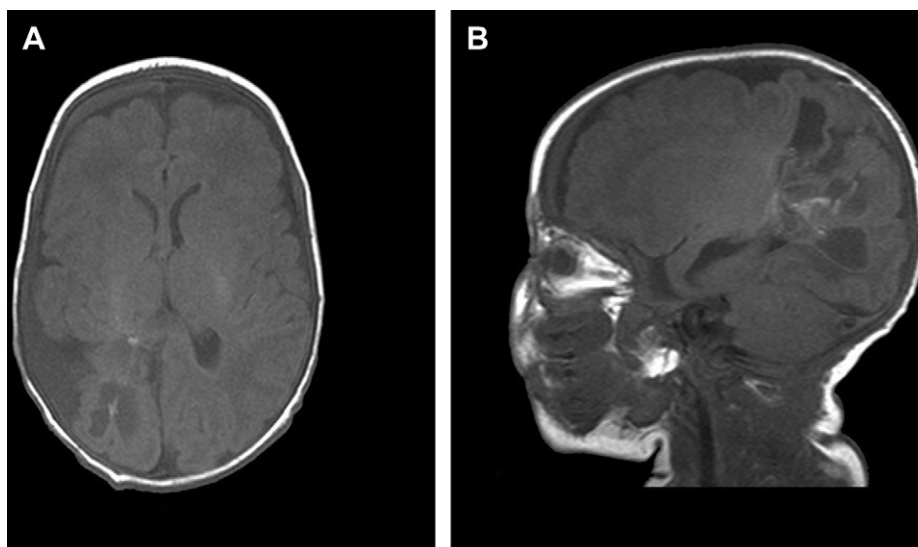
Postoperative magnetic resonance imaging of the brain showing (A) right-sided cortical thinning and atrophy with temporo-parietal gliosis and (B) *ex vacuo* dilatation of the temporal horn.
